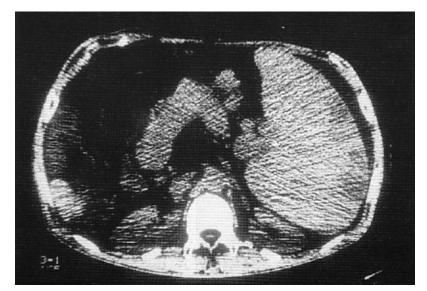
Post-embolization CT, shows multiple, small hypodense areas of subcapsular infarctions.
